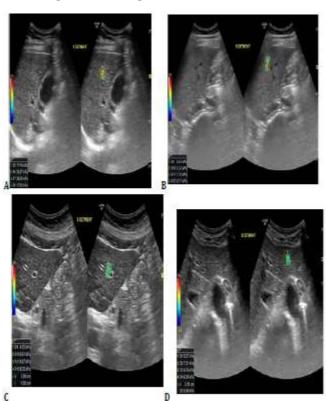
Ultrasound images of the liver parenchyma at different stages of fibrosis in 2D (left) and 2D SWE (right). A - liver fibrosis at stage F1; B - liver fibrosis at stage F2; C - liver fibrosis at stage F3; D - liver fibrosis at stage F4 (explanation in text).
